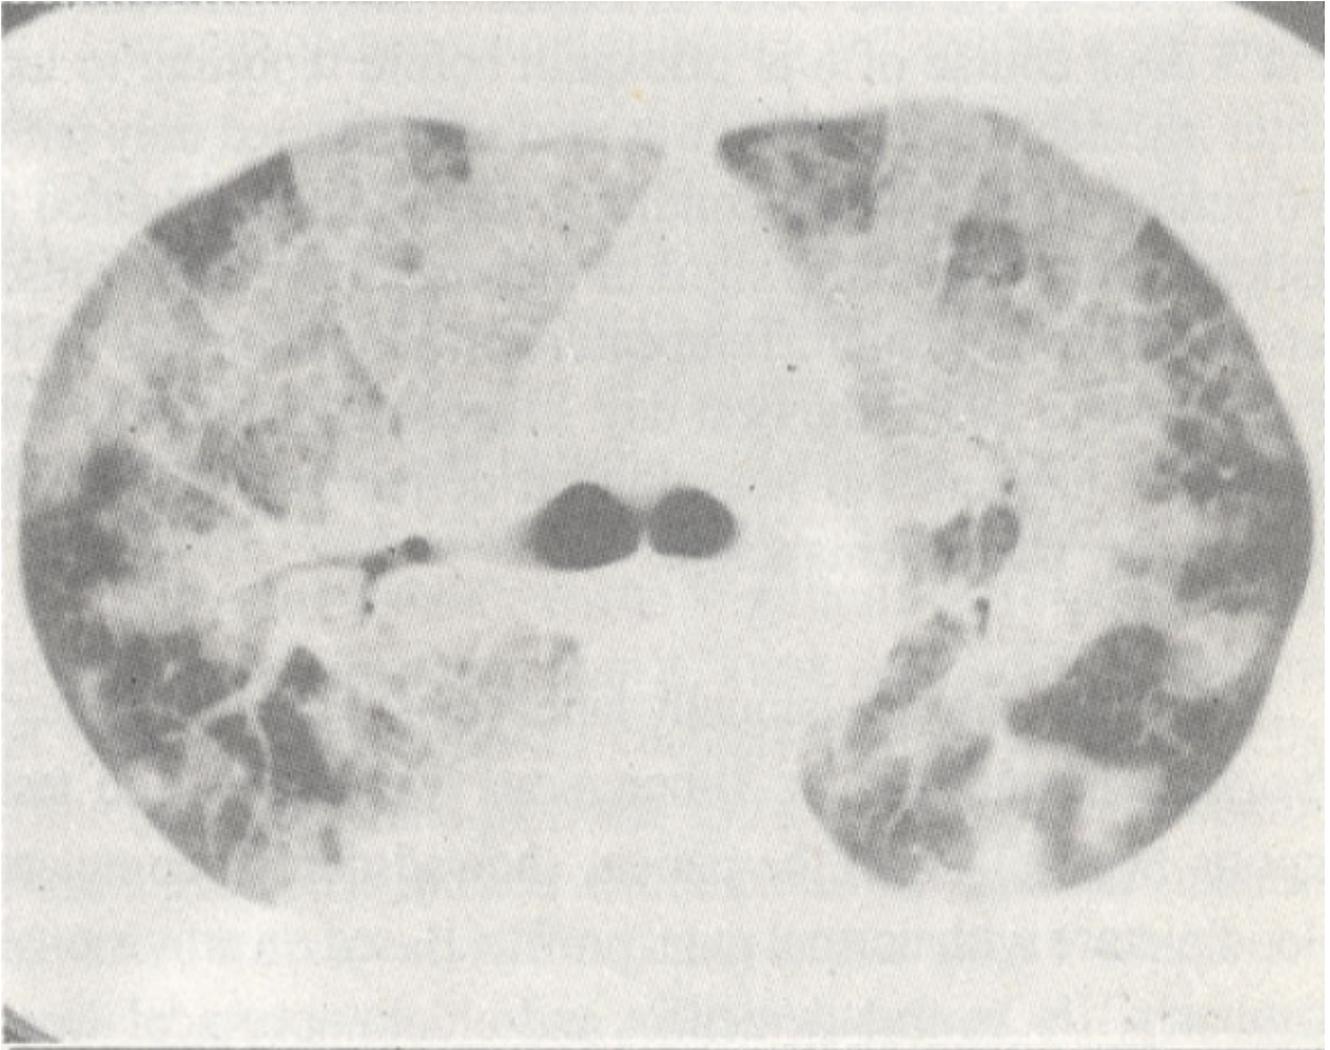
Computed tomography of the chest.
